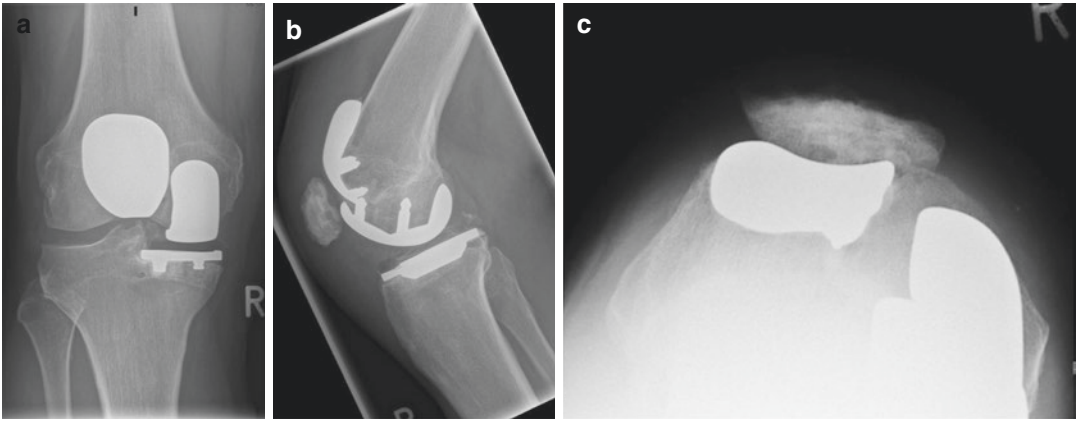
Radiographs in antero-posterior (a) and lateral (b) and Merchant view (c) of bicompartamental replacement of a right knee using a patellofemoral implant and unicondylar implant separately
